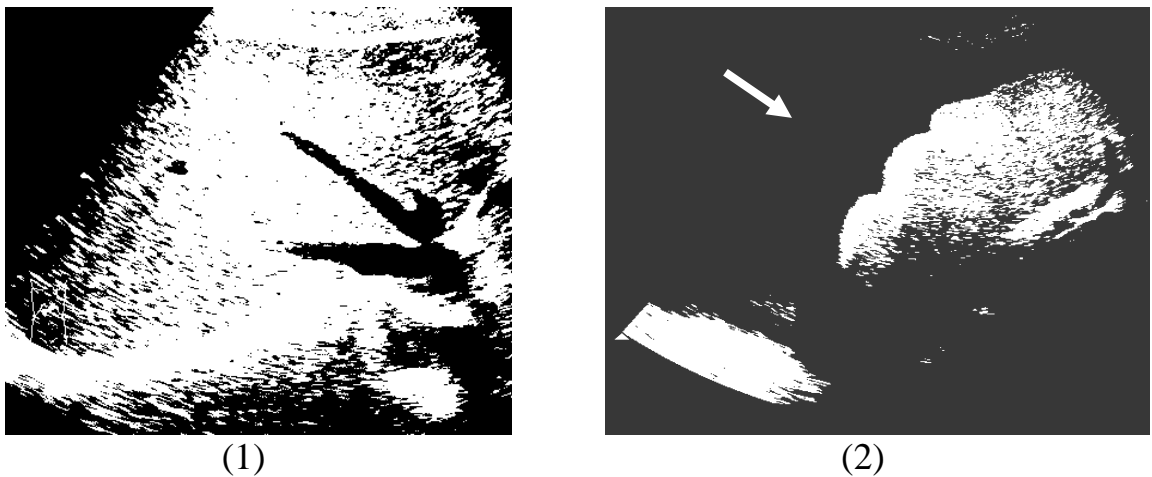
Liver ultrasound examination:
